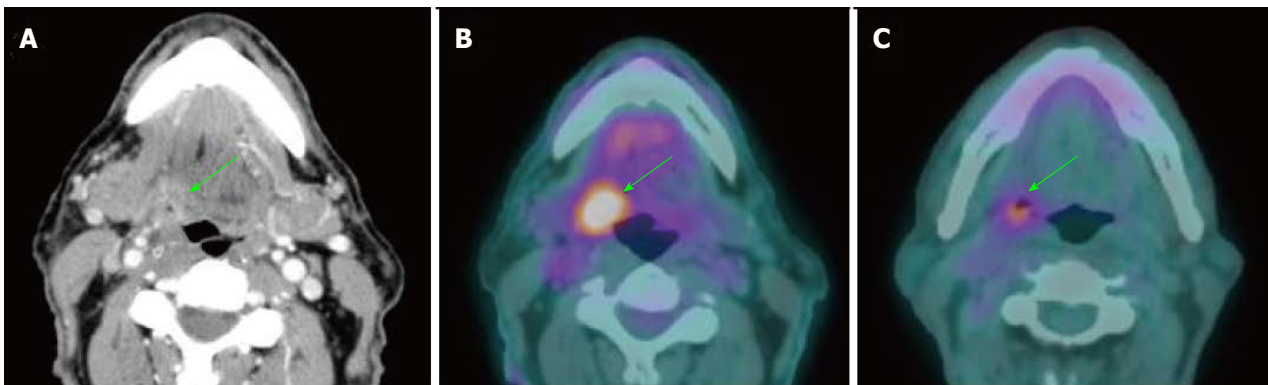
Residual primary tumor. Squamous cell carcinoma of the right base of tongue (arrows) was identified on contrast-enhanced CT (A) and pre-treatment PET/CT (B) with maximal SUV: 10.2. The tumor remained FDG-avid on PET/CT (C) with maximal SUV: 4.8 at 12 wk after treatment, representing residual disease. PET/CT: Positron-emission tomography/computed tomography; SUV: Standardized uptake value.
